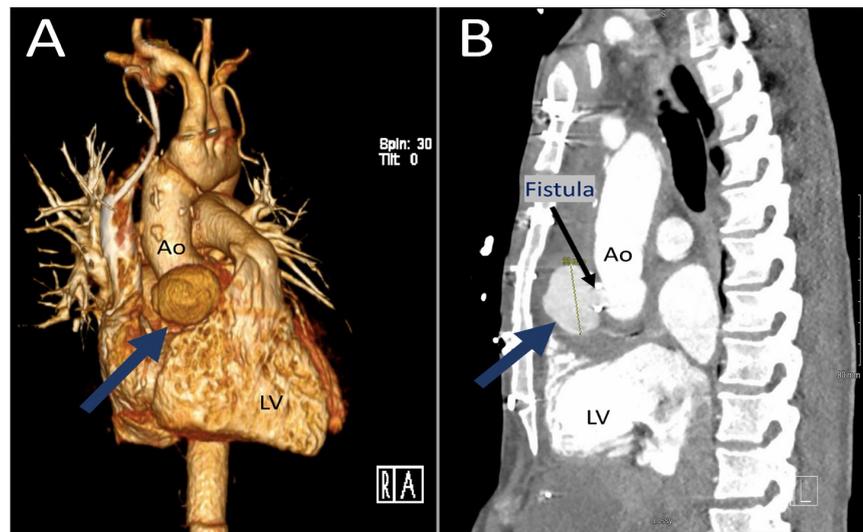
(A) 3-dimensional reconstruction of chest computerized tomography (CT) with blue arrow pointing to pseudoaneurysm. (B) Sagittal view of chest CT scan showing the same pseudoaneurysm with blue arrow, and fistulous connection as marked by black arrow.
